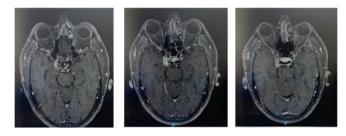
MRI brain axial T1 post-contrast images from his initial presentation. shows an enhancing soft tissue thickening along right cavernous sinus, without any filling defect in the cavernous sinus or dilated SOV.
